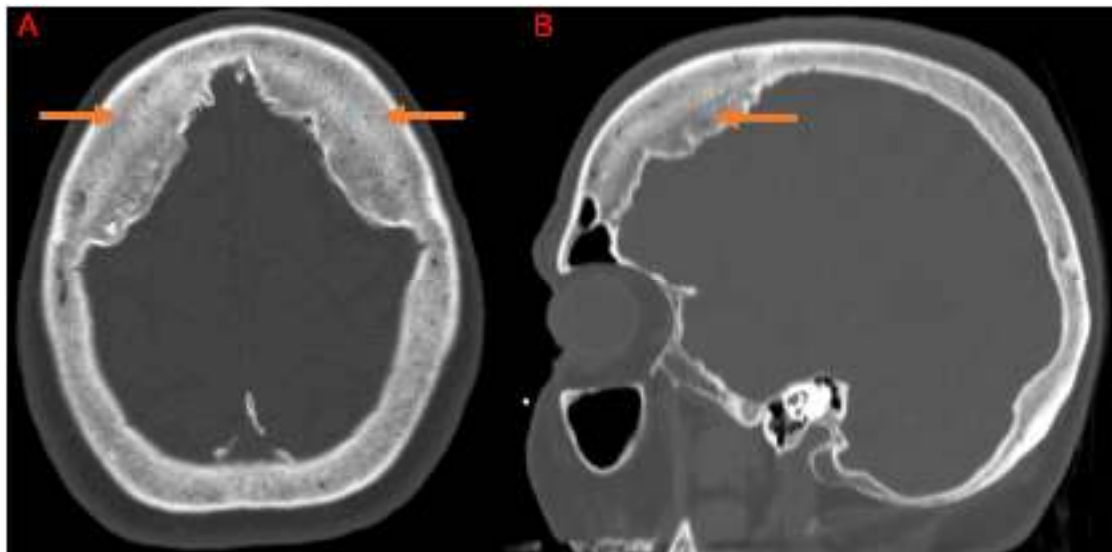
No prior imaging was available for comparison. Therefore, head CT was performed for evaluation. This showed diffuse thickening of the calvarium, most prominent in the frontal regions, without destructive marrow replacing lesion (A, B).
